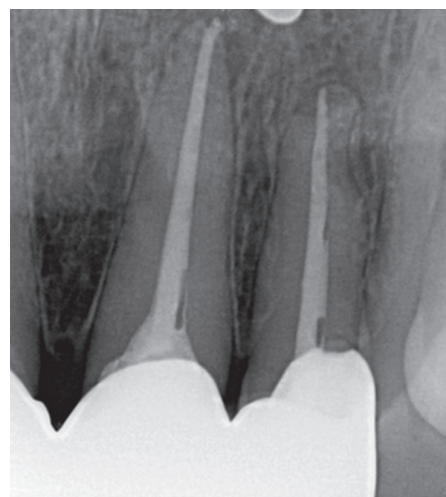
Postoperative intraoral radiograph of the tooth 2.2
